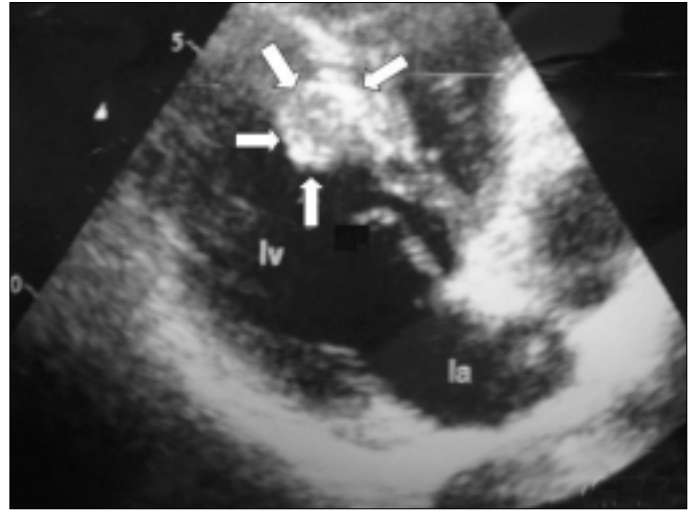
The echocardiographic image demonstrates cardiac hydatid cyst, 1.9x1.3 cm in size, located in interventricular septum (Arrowhead)
